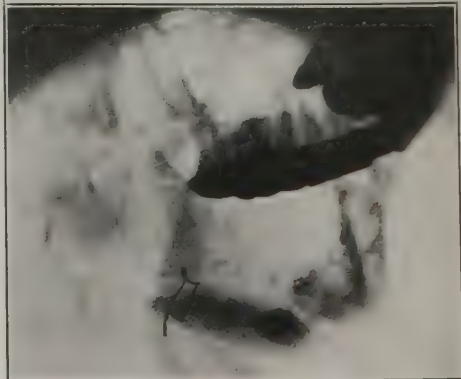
Case 6: Radiograph showing tibial graft in position.
